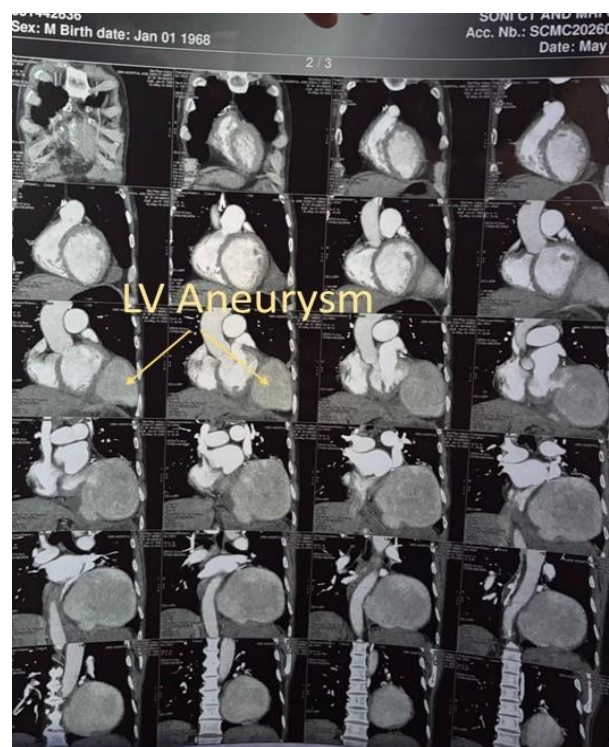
CT cardiac chambers showing outpouching arising from the left lateral wall of the left ventricle with irregular hyperdensities suggestive of thrombus.
